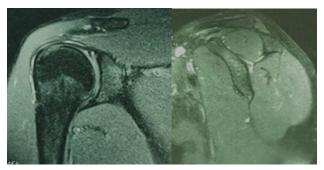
MRI reexamination showed no recurrence of the cyst
